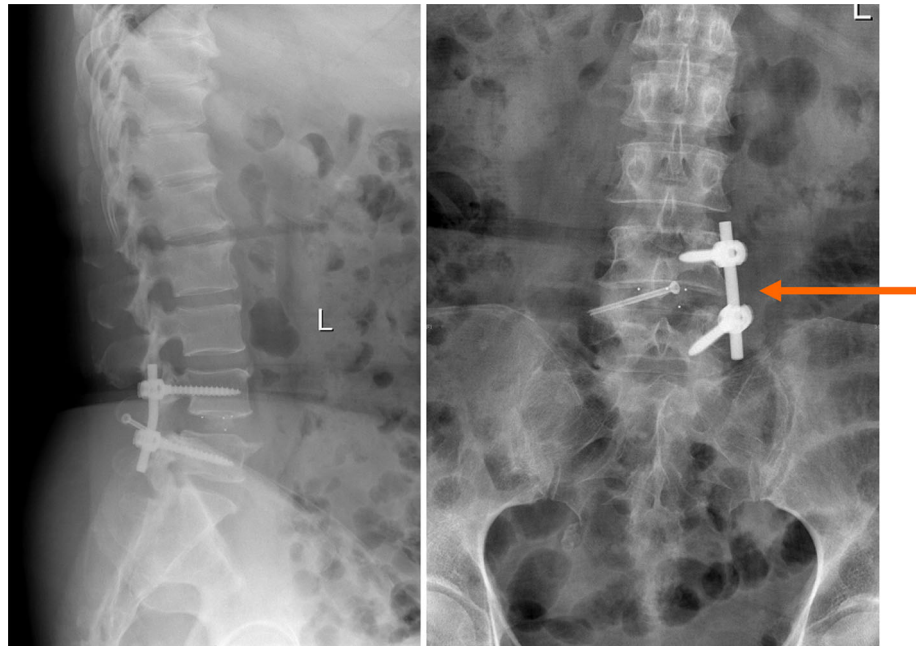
X-ray showed TLIF with UPS+TFS fixation
